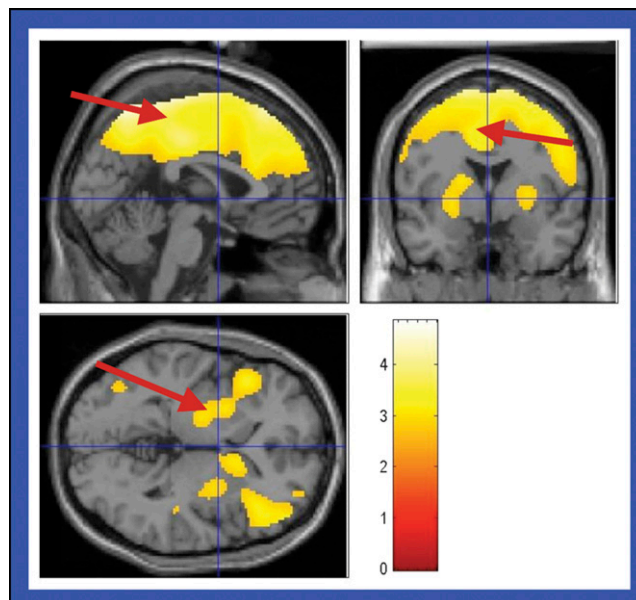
^{18}F -FDG PET showed increased regional glucose metabolism in the parietal cortex, singulate cortex, and striatum when individuals performed numerical tasks with methylphenidate pretreatment.
